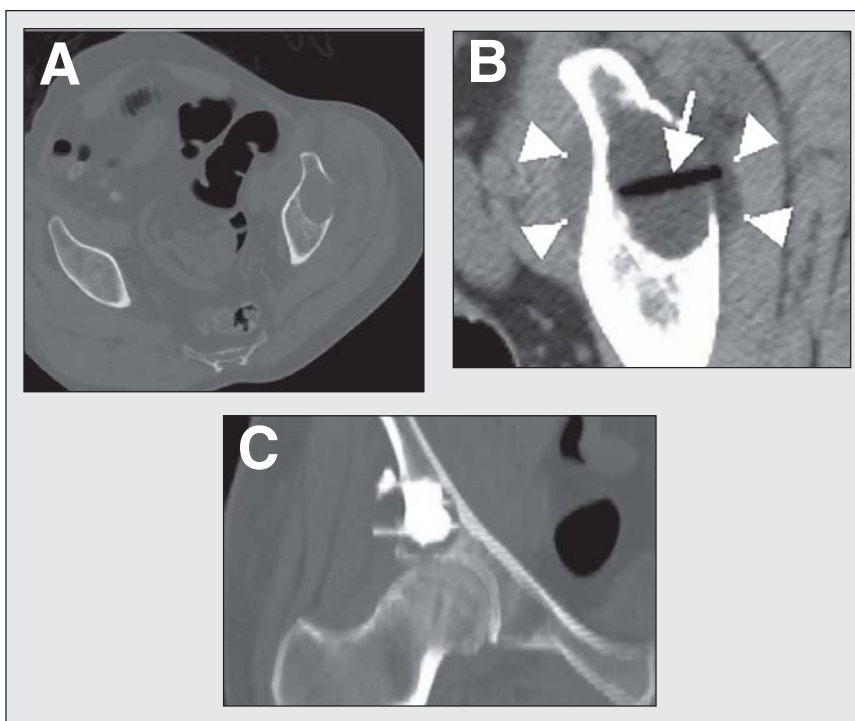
Formation of Iceball and Follow-up CT—(A) Noncontrast CT demonstrates osteolytic metastasis involving the right periacetabular region. (B) Noncontrast CT immediately following removal of the cryoprobe with probe tract (arrow) in the center of the low-attenuation iceball (arrowheads). Iceball completely encompasses the metastatic tumor. (C) Coronal noncontrast CT following cementoplasty. CT = computed tomography.
